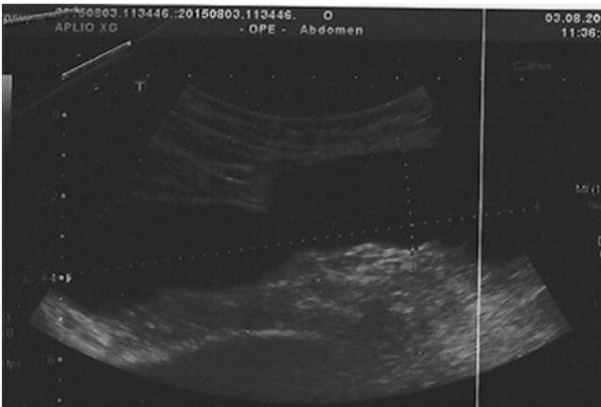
Ultrasound examination. Visible unicameral cyst extending from the labia majora into the inguinal canal
